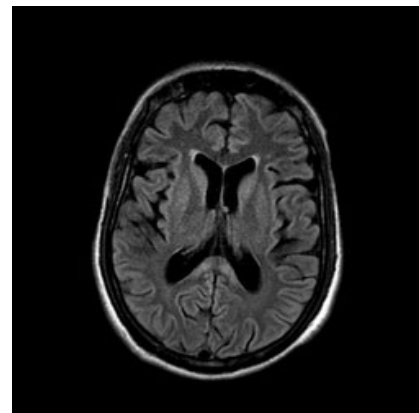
Axial FLAIR image at the same level
